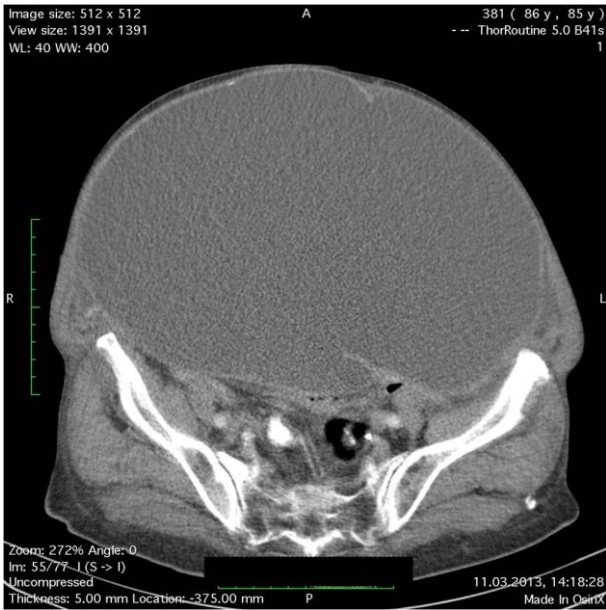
CT aspect: a large mass at the abdominal level
